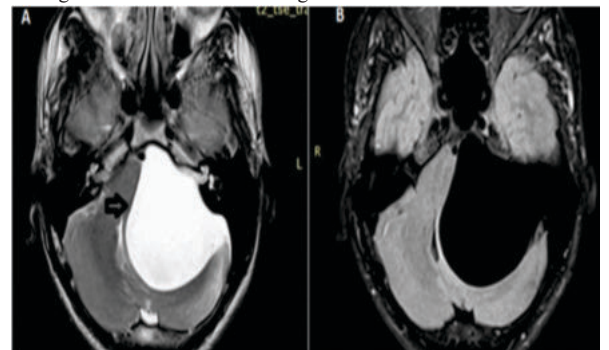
Arachnoid cyst. A: Well-defined lesion following CSF intensity on T2 weighted axial section; B: Same lesion in axial FLAIR image.
